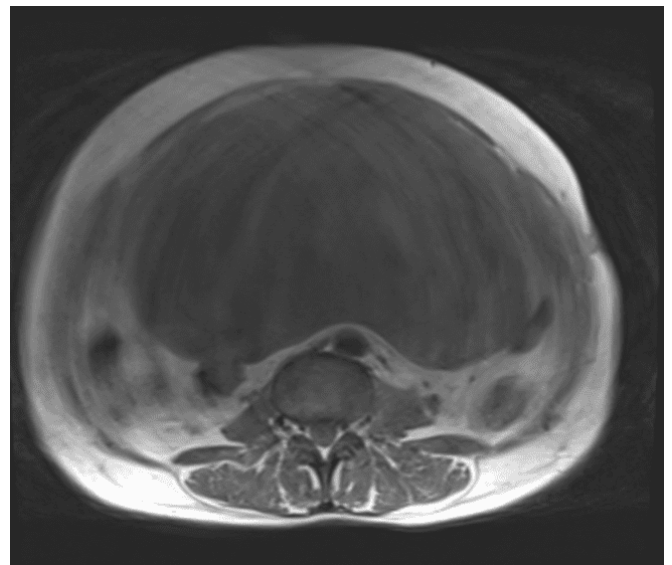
Axial T1-weighted MRI demonstrating a predominantly hypointense giant pelvi-abdominal mass.
